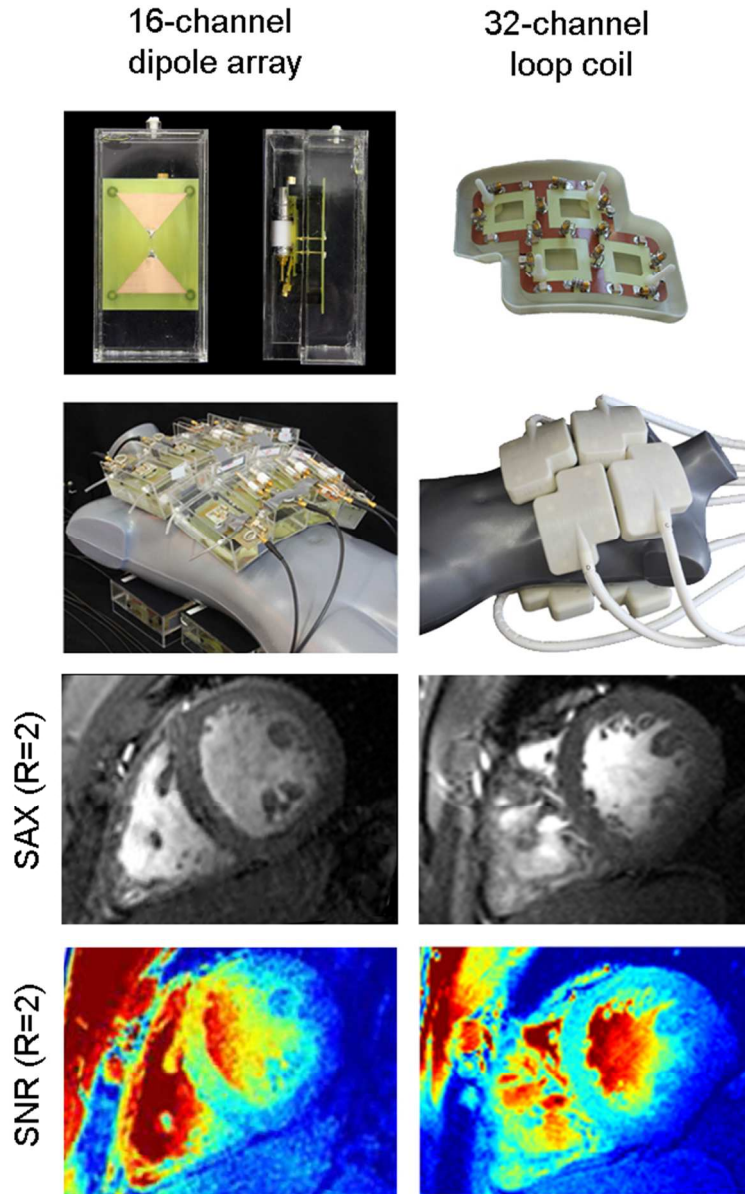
SNR comparison of a 16-channel bow tie dipole array (120) and a 32-channel loop coil array (124) for cardiac imaging at 7.0 T. A 2D CiNE FLASH of a short axis view (SAX) ($1.1 \times 1.1 \times 2.5$ mm²) and its corresponding SNR map (122, 123) is displayed for a GRAPPA reduction factor $R=2$. The 16-channel bow tie dipole array shows higher mean SNR values as compared to the 32-channel loop coil indicating its feasibility for MRI at UHF ($B_0 = 7.0$ T) (120). The excellent image quality obtained from using dipole antennas for MRI demonstrates the rationale of these elements to be used for an integrated system.
